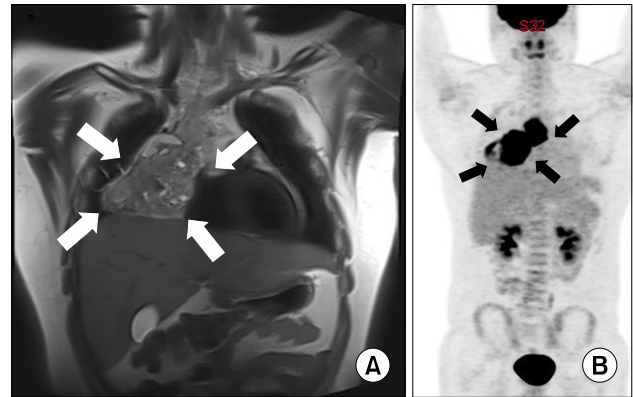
Chest MRI (A) with heterogeneous enhancing mass at the Rt. anterior mediastinum (white arrow), PET-CT (B) with increased FDG uptake in the anterior mediastinal mass, suggesting malignancy (black arrow).
